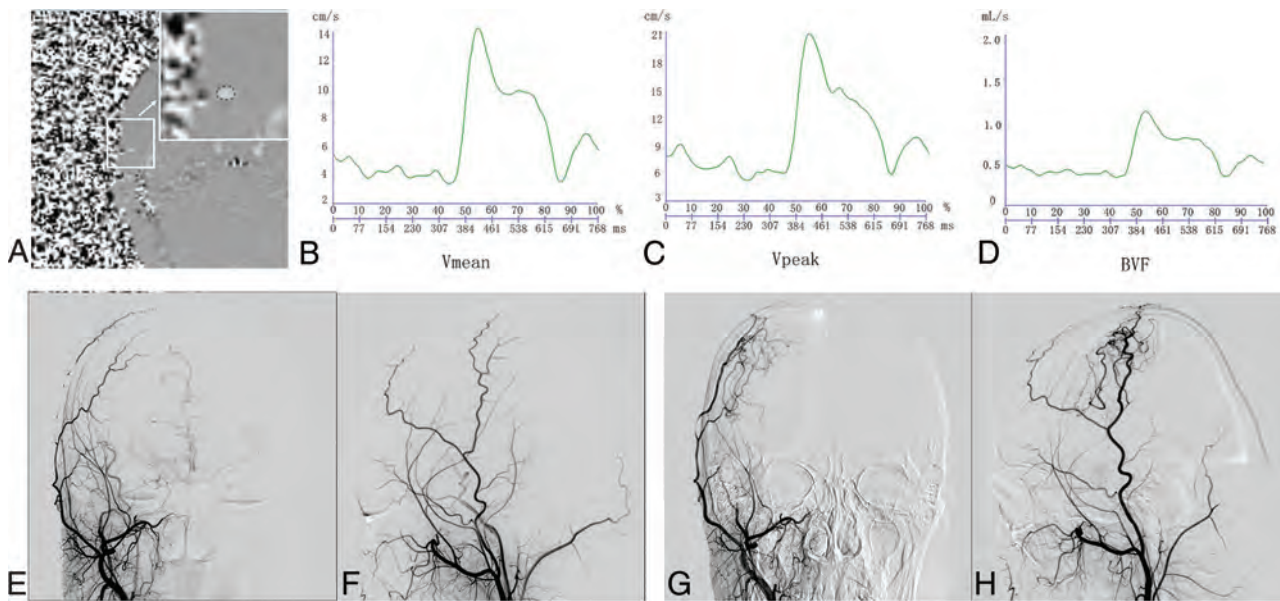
PC-MR imaging and DSA examination in a patient with poor collateral formation. Images in a male patient diagnosed with MMD who had right EDAS surgery. He underwent PC-MRI and DSA before and 7 months after the operation. A, Phase image shows the ROI of the right STA. A, the *arrow* represents the enlarged view of the small white square. Modulation of Vmean (B), Vpeak (C), and BVF (D) of the right STA acquired by PC-MRI. Anterior-posterior and lateral projections of preoperative (E and F) and postoperative (G and H) DSAs of right external carotid artery show small areas of revascularization (less than one-third of the MCA territory).
